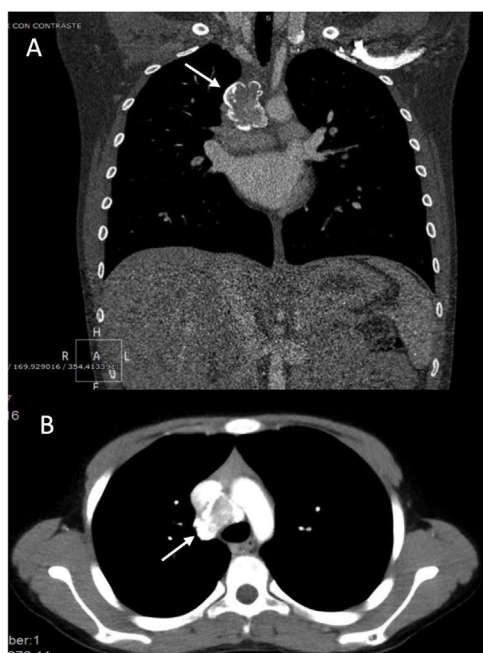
Chest CT scan with contrast A: right paratracheal nodular lesion with calcification in coronal section. B: same lesion in axial section.
